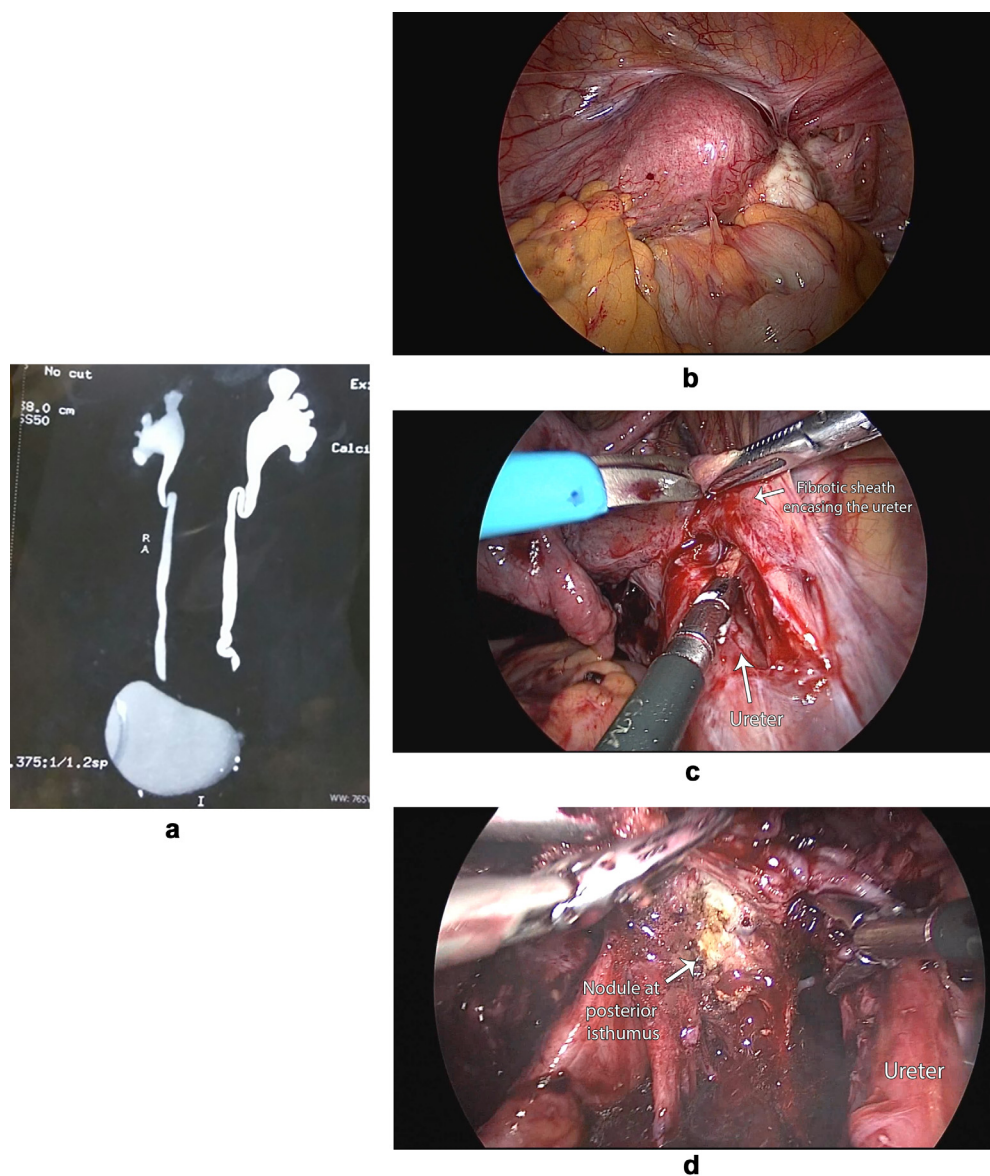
(a) CT urogram showing bilateral hydroureter and hydronephrosis. (b) Complete obliteration of bilateral hemipelvis. (c) Ureterolysis including release of ureter from surrounding fibrotic sheath. (d) Resection of fibrotic nodule at posterior isthmus.
